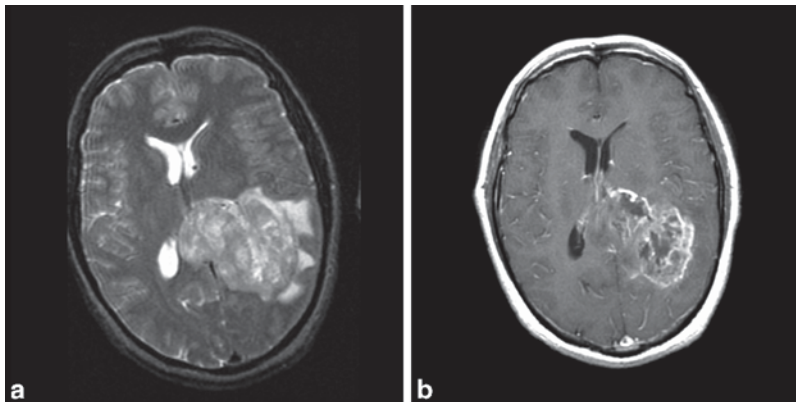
a Axial, T2-weighted MRI showing left parietal glioblastoma multiforme extending into corpus callosum with surrounding vasogenic edema and causing midline
